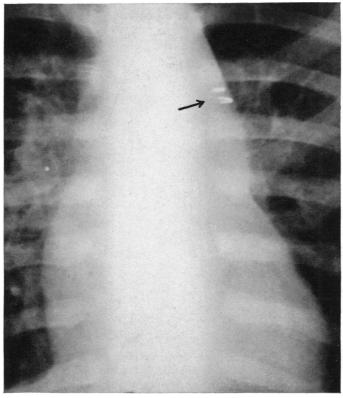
Case 3: Roentgenogram of heart following operation to show position of the two silver clips which were placed on the ductus ties to identify this region. The obliterated ductus is a few millimeters medial to these clips.
